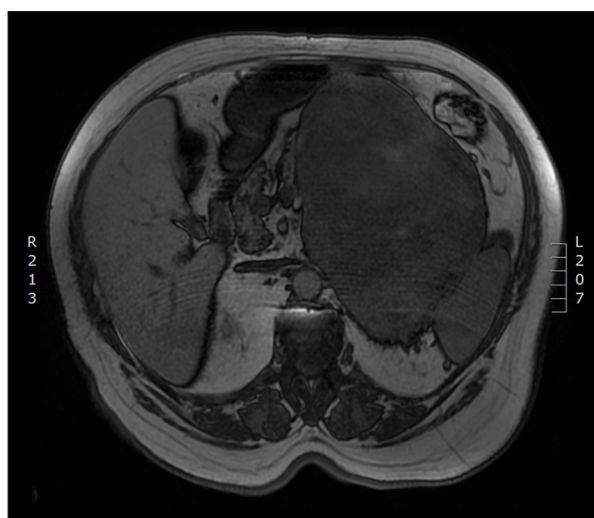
MRI scan with abdominal mass next to the left kidney.
